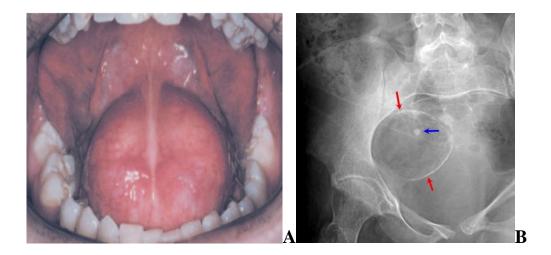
A-Dermoid cyst. Fluctuant midline swelling in the floor of the mouth. (Budnick, 1981) B- close-up view of the right lower quadrant from a conventional radiograph of the abdomen and pelvis shows a cystic mass with a rim-like calcification (red arrows) containing fat density lower than that of the surrounding soft tissue. There is a calcification within the mass (blue arrow). (William, 2019)
